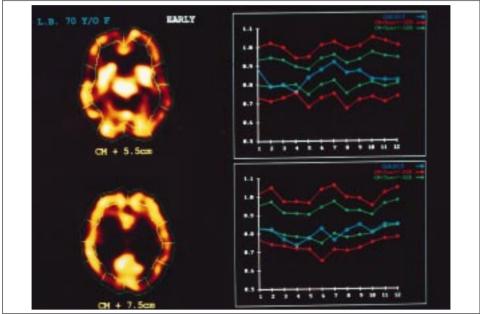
(d) Tc-99m HMPAO brain SPECT scan sections from the one week post-stroke scan positioned parallel to and 5.5 cm (top left) and 7.5 cm (bottom left) above the canthomeatal line. To the right of the images are shown the semi-quantitative cortical circumferential profile of the cortical to cerebellar indices as described in the text. The blue line represents the patient, the green line represents one standard deviation from age matched normal controls (n = 9), and the red line indicates two standard deviations from the mean of age-matched normal controls. The x axis represents cortical regions progressing from the twelve to one o'clock position (cortical region #11) to the eleven to twelve o'clock position (cortical region #112). The y axis has the units of cortical region counts divided by cerebellar counts. The semi-quantitative curves show reduction of regional cerebral blood flow in the left temporal region (top curve region 4 at canthomeatal + 5.5 cm). The bottom curve shows reduction of left posterior parietal cerebral blood flow.
